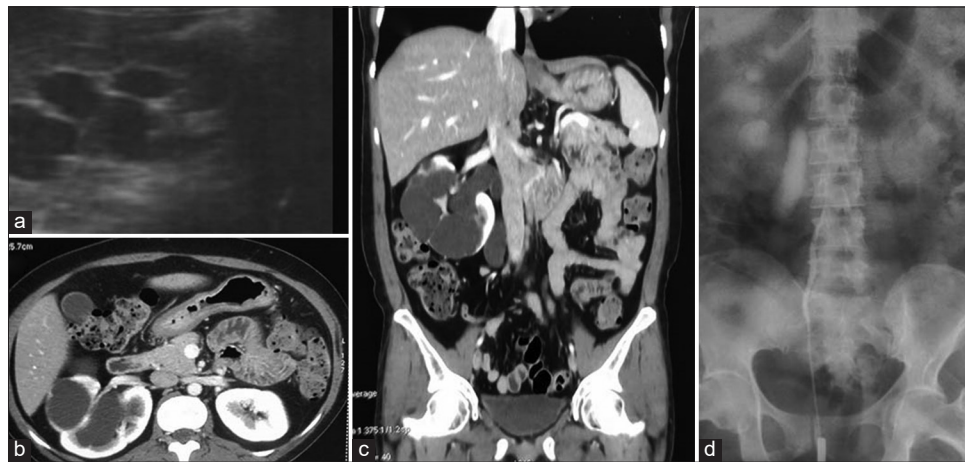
(a) Ultrasound showing the right gross hydronephrosis. (b and c) Computed tomography showing inferior vena cava and right ureter coursing behind it. The right side Grade IV hydronephrosis. (d) Retrograde pyelography showing “fishhook sign”
